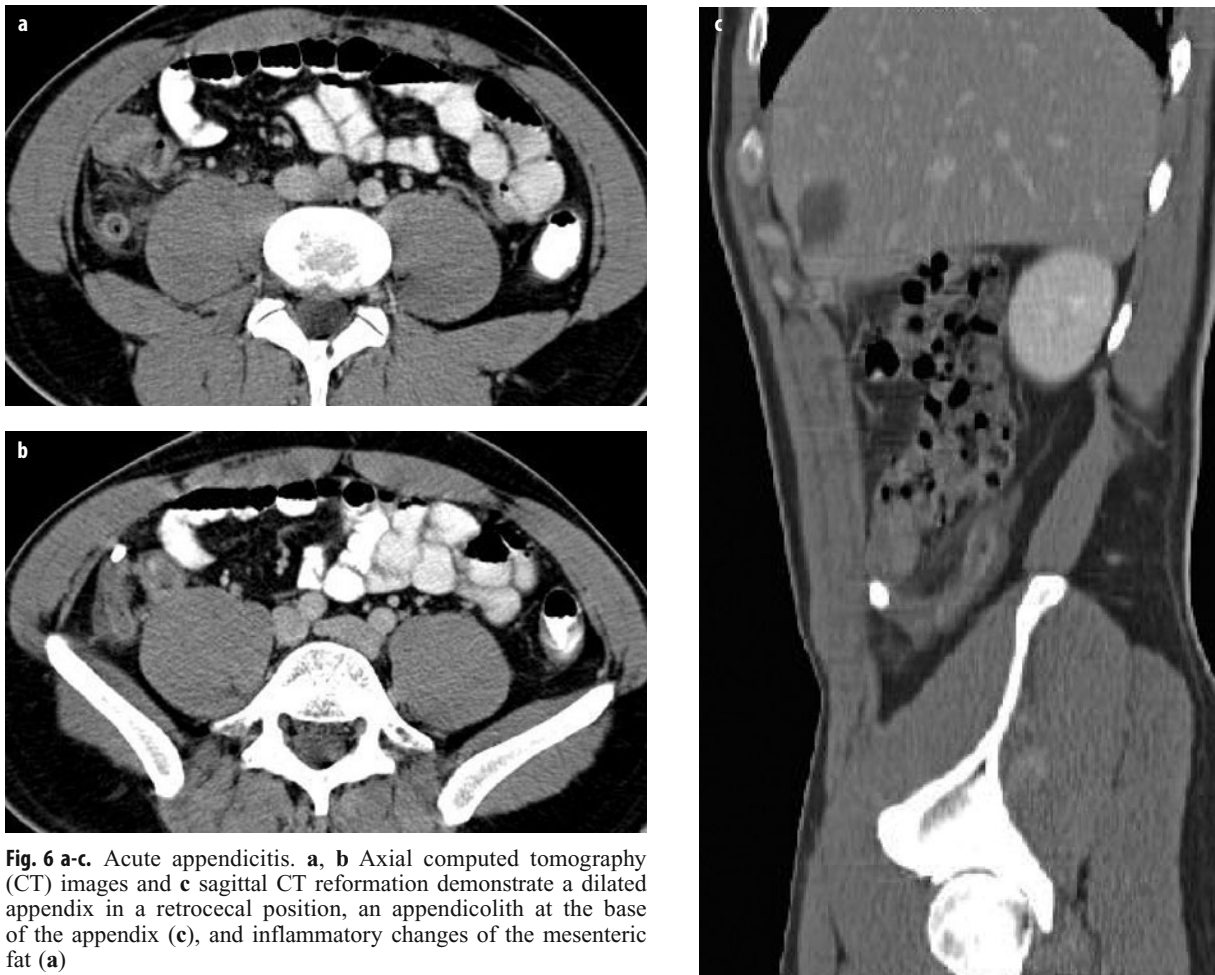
a-c. Acute appendicitis. a, b Axial computed tomography (CT) images and c sagittal CT reformation demonstrate a dilated appendix in a retrocecal position, an appendicolith at the base of the appendix (c), and inflammatory changes of the mesenteric fat (a)
